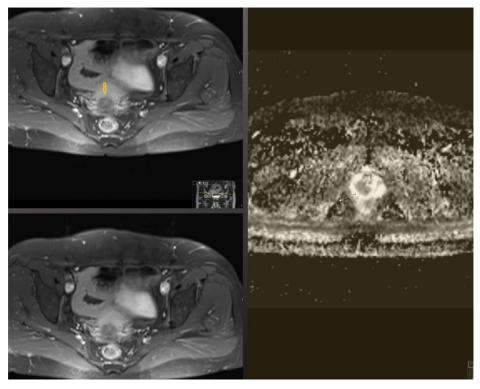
Magnetic resonance imaging (MRI) of vaginal metastasis.
